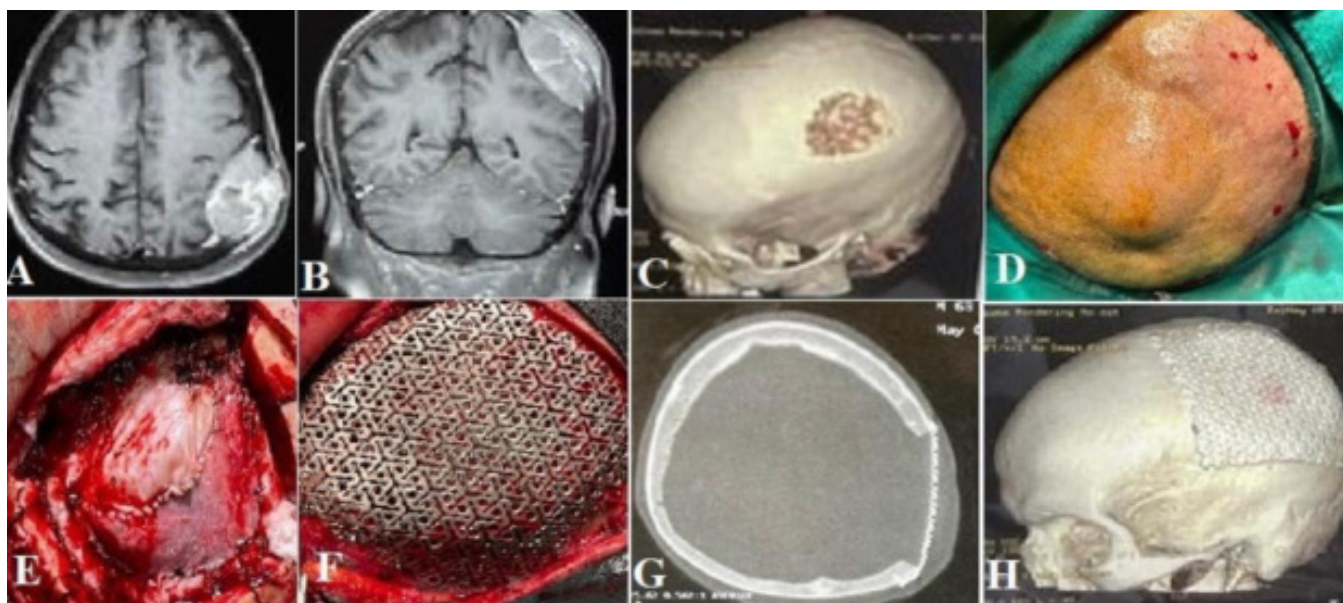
A) Axial magnetic resonance imaging (MRI) T1 weighted images (WI) with contrast showing intensely enhancing mass at left high parietal area with evident dural attachment and enhancement. B) Coronal MRI T1 WI with contrast showing the same lesion. C) 3-D reconstructed CT image showing skull bone erosion and defect at left high parietal area. D) Intraoperative photo showing the mass emerging to the subcutaneous spaces and the planned skin incision for removal of the lesion. E) Intraoperative photo showing complete removal of the lesion with parts of the dura and dural graft exposed underneath the removed pathological bone flap. F) Intraoperative photo showing designed metallic titanium mesh completely covering the bony defect. G) Axial bone window CT image showing the mesh at the site of the defect. H) 3-D reconstructed CT image showing well positioned titanium mesh at the site of the lesion after its complete excision with pathological dura and bone.
